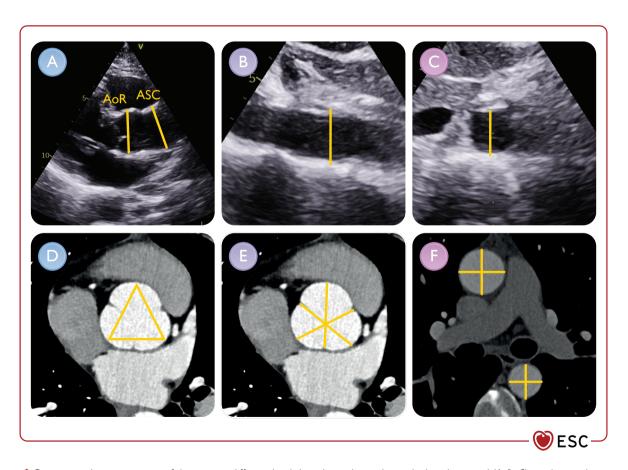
Conventional measurements of the aorta at different levels by echocardiography or duplex ultrasound (A, B, C), cardiovascular computed tomography or cardiovascular magnetic resonance (D, E, F). (A) Echocardiographic measurements of the aortic root and ascending aorta using the leading-to-leading edge methodology. (B) The outer-to-outer convention in the abdominal aorta in cases with aortic wall disease in a longitudinal view. This method can be used in a non-circular section as an alternative. (C) The outer-to-outer antero-posterior diameter of the abdominal aorta in a cross-sectional view. Evaluation of the aortic root using the cusp-to-cusp diameter (D) and the cusp-to-commissure convention (E); (F) measurement of the ascending aorta and the descending aorta with the double-oblique technique. AoR, aortic root; ASC, proximal ascending aorta.
